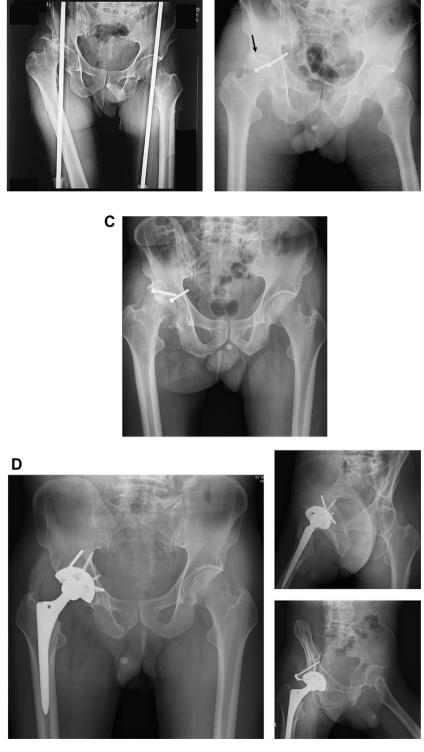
(A) Radiographs of a 62-year-old man who had a posterior wall fracture-dislocation of the right acetabulum. (B) Anteroposterior radiograph taken after ORIF with the Kocher–Langenbeck approach was performed on the day of injury. Reduction was graded as imperfect (red arrow indicates the 2-mm residual fracture gap). (C) Anteroposterior radiographs taken 1 month after injury. Loss of reduction with loosening of the screws resulted in femoral head dislocation. (D) Anteroposterior and 45° oblique radiographs taken 1 year after injury showing total hip arthroplasty with union of the autogenous bone graft for the previous failed surgery. ORIF = open reduction and internal fixation.
